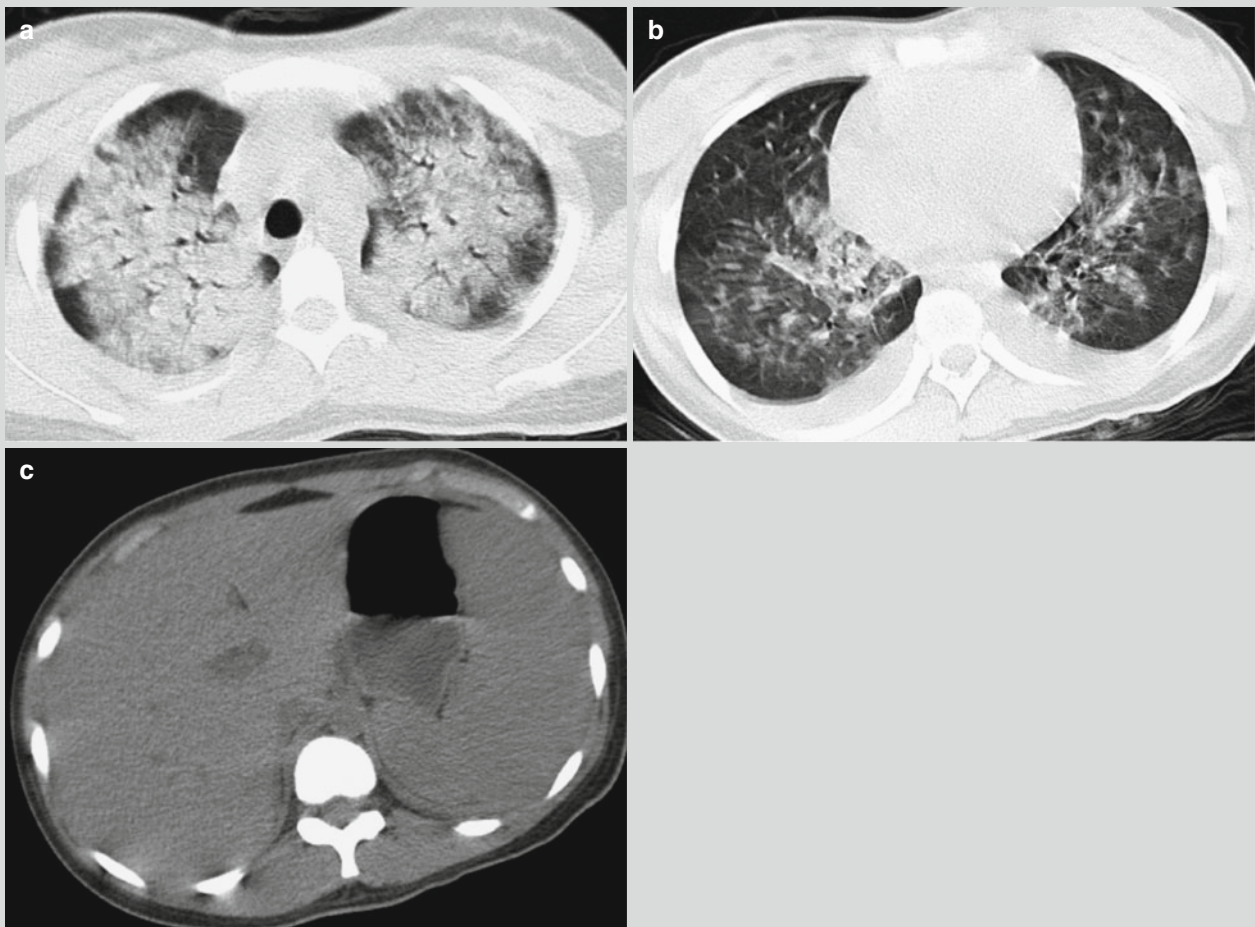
Multiple organ involvement of malaria with pulmonary edema, pleural effusion, and hepatosplenomegaly. (a, b) CT scanning demonstrates diffusive distribution of ground-glass
